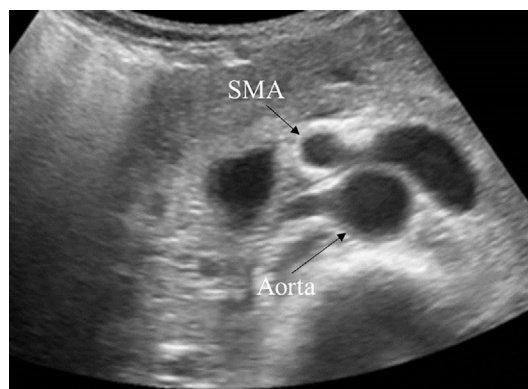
An abdominal transverse ultrasonography image for measuring the distance between the SMA and aorta where the duodenum passes. SMA: superior mesenteric artery
